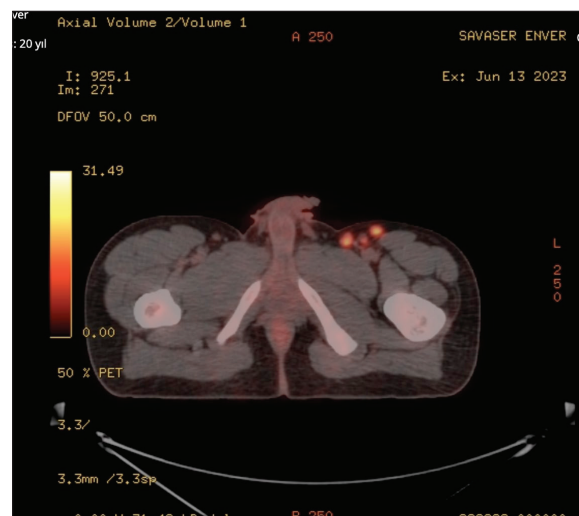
PET CT shows increased/intensely increased ^{18}F -FDG uptake in multiple lymph nodes in the left inguinal lymphatic nodes.
